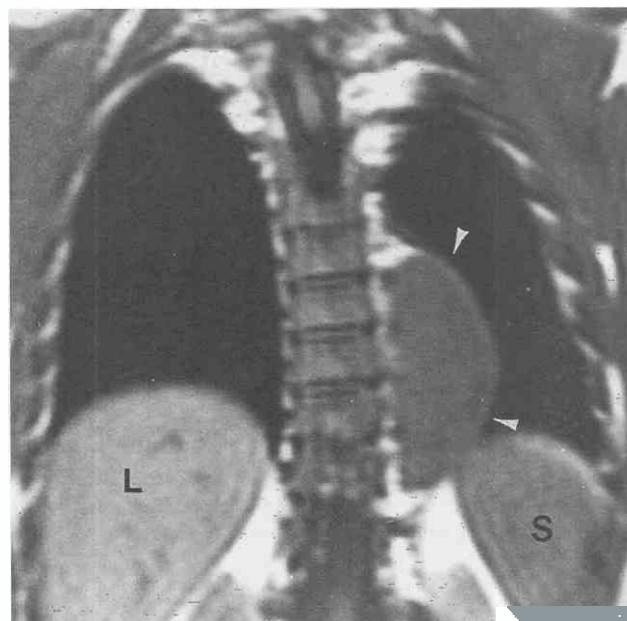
Ganglioneuroma. Coronal T1-weighted MR image shows an elliptical paraspinal mass (arrowheads) of intermediate signal intensity. Vertical orientation and signal characteristics are typical of a sympathetic ganglion tumor. L, liver; S, spleen.
